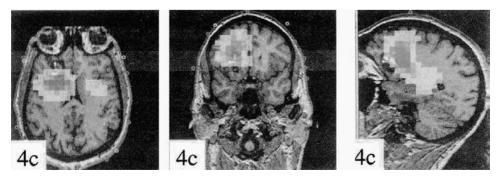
LORETA solutions for ictal epileptic data, overlay on axial, coronal and saggital 3DT1 MRI. Reproduced with permission from Worell *et al.* (2000), <sup>148</sup> ©Human Sciences Press, Inc.
